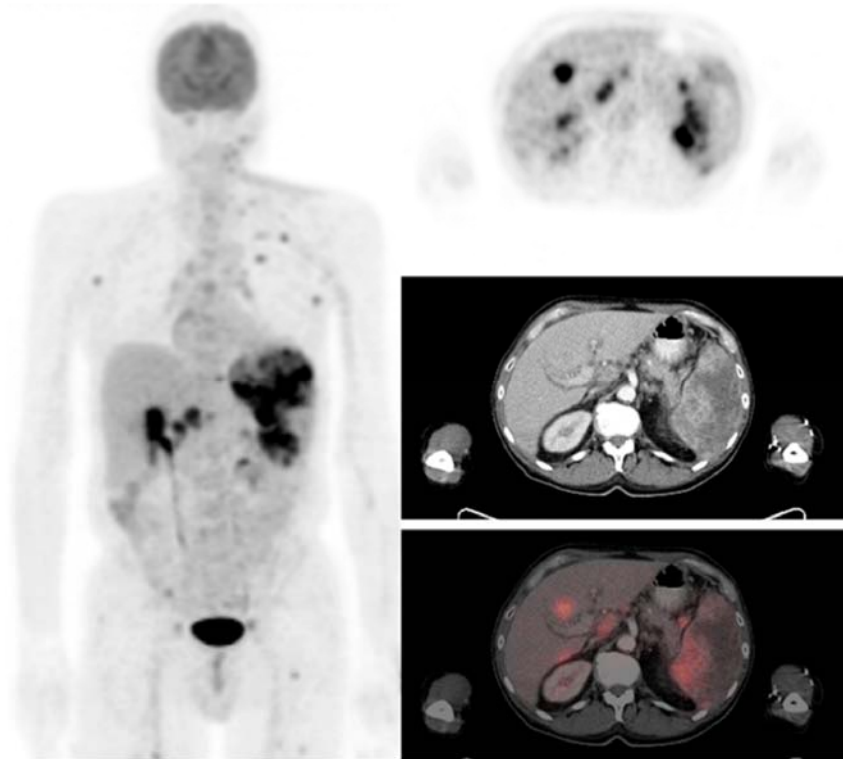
A 58-year-old male with a history of malignant melanoma resected from his scalp followed by left neck dissection 6 months later for the removal of metastatic cervical lymph nodes. Images of FDG PET/CT scan obtained 6 months after neck dissection are shown. Images show splenic, hepatic, and multiple lymph node metastases of malignant melanoma.
